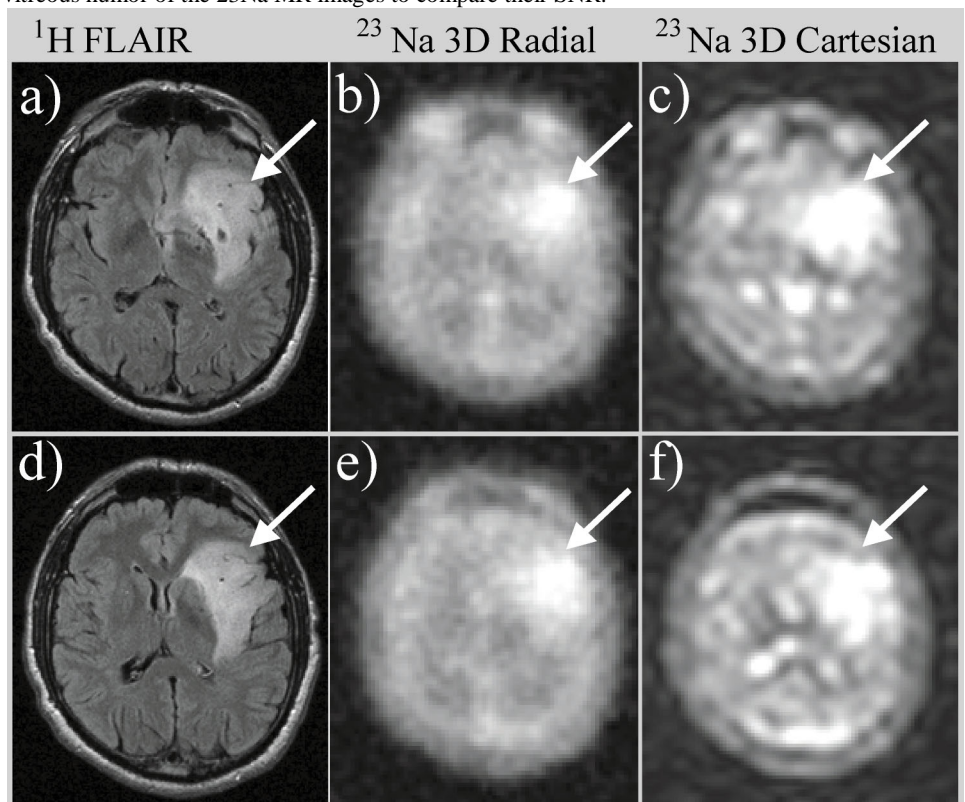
Images of a patient with low grade glioma: ^1H FLAIR images (a,d), ^{23}Na 3D radial (b,e) and cartesian (c,f) GRE images. The higher signal intensity area in the ^{23}Na images corresponds to that in the ^1H images.
